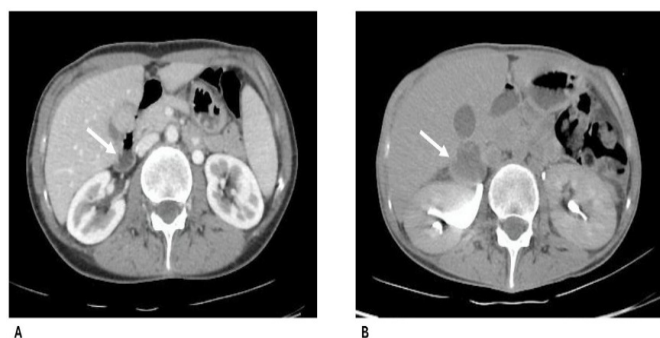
Radiological evolution of the right adrenal metastasis. (A) Contrast-enhanced CT demonstrating a newly detected, well-defined 13 × 11 mm right adrenal lesion. (B) Follow-up contrast-enhanced CT showing progression to a large heterogeneous right adrenal mass with areas of necrosis.
